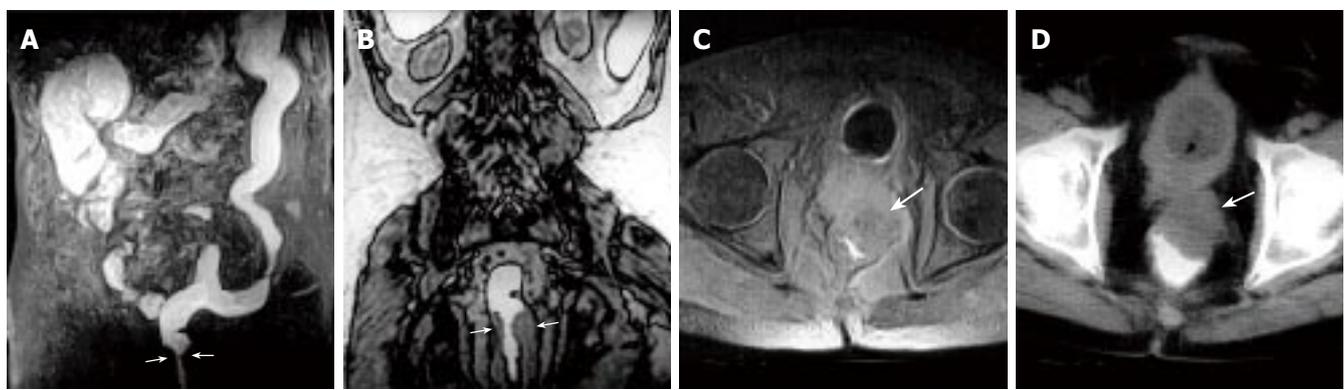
A 63-year-old man with rectum carcinoma invasion to prostate. A: MR colonography MIP (maximum intensity projection) image showing luminal narrowing at rectum (arrows); B: MR colonography raw data coronal image showing luminal narrowing due to annular thickening of the rectum wall (arrows); C: SE axial T1W image; D: axial CT image showing asymmetric wall thickening at rectum (arrows), and invasion to the fatty tissue around the mass.
